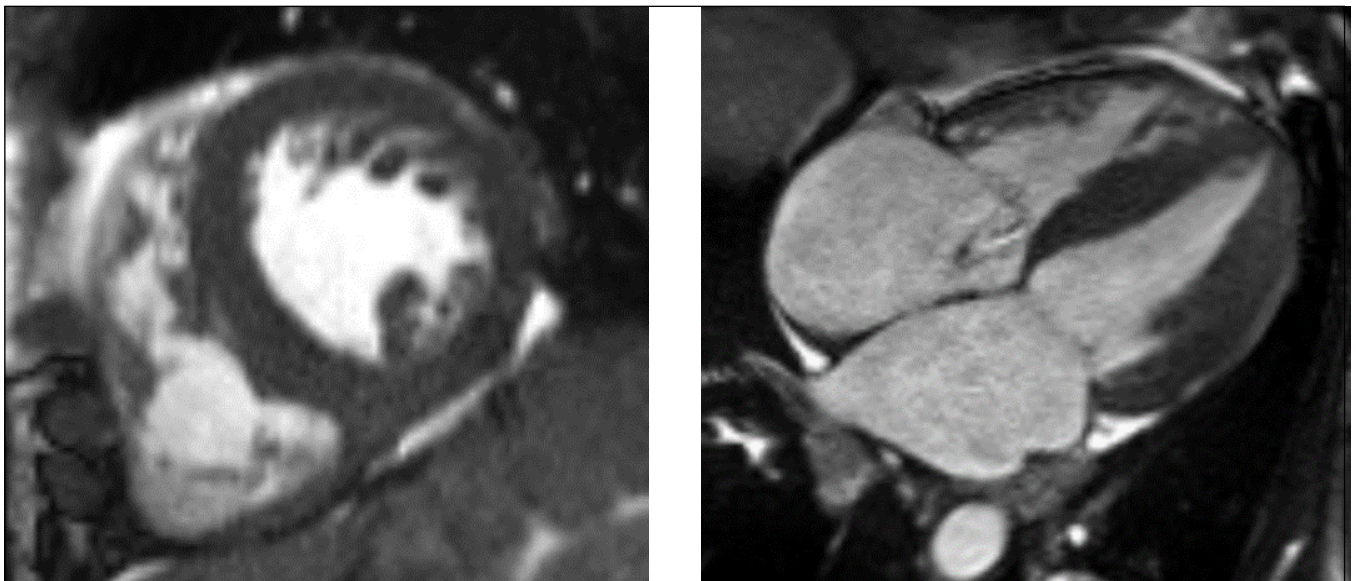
Cardiac MRI with intravenous contrast. MRI signs of restrictive cardiomyopathy, high likelihood of infiltrative myocardial damage (amyloidosis). There were no findings consistent with myocardial fibroelastosis or constrictive pericarditis. MRI did not reveal signs of edema, inflammatory infiltration, or post-inflammatory/post-ischemic fibrosis.
